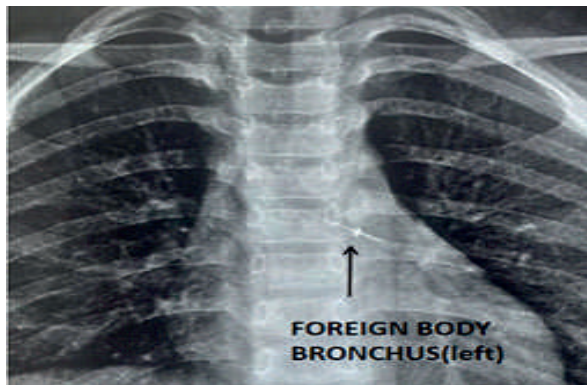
X-ray chest showing a radio-opaque foreign body in left main bronchus.
